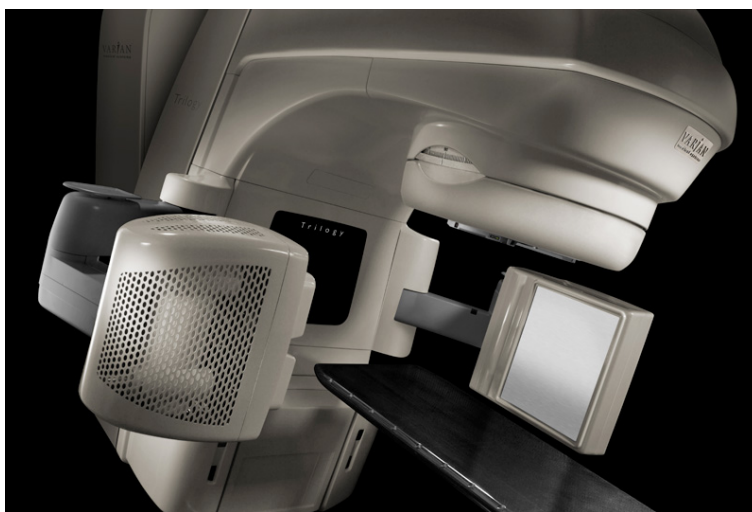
The Varian On-Board Imager kV imaging system (OBI) consists of a kV x-ray source and flat-panel imager mounted to a linac gantry. Courtesy of Varian Medical Systems (Palo Alto, CA).
